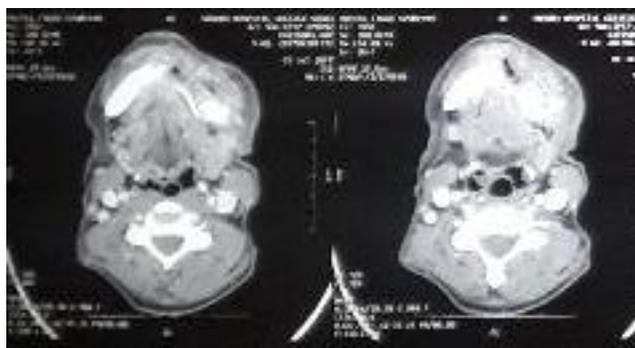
Computed tomography after injection of contrast in soft tissue window showed an osteolytic lesion in left posterior mandible associated with cortical erosion
